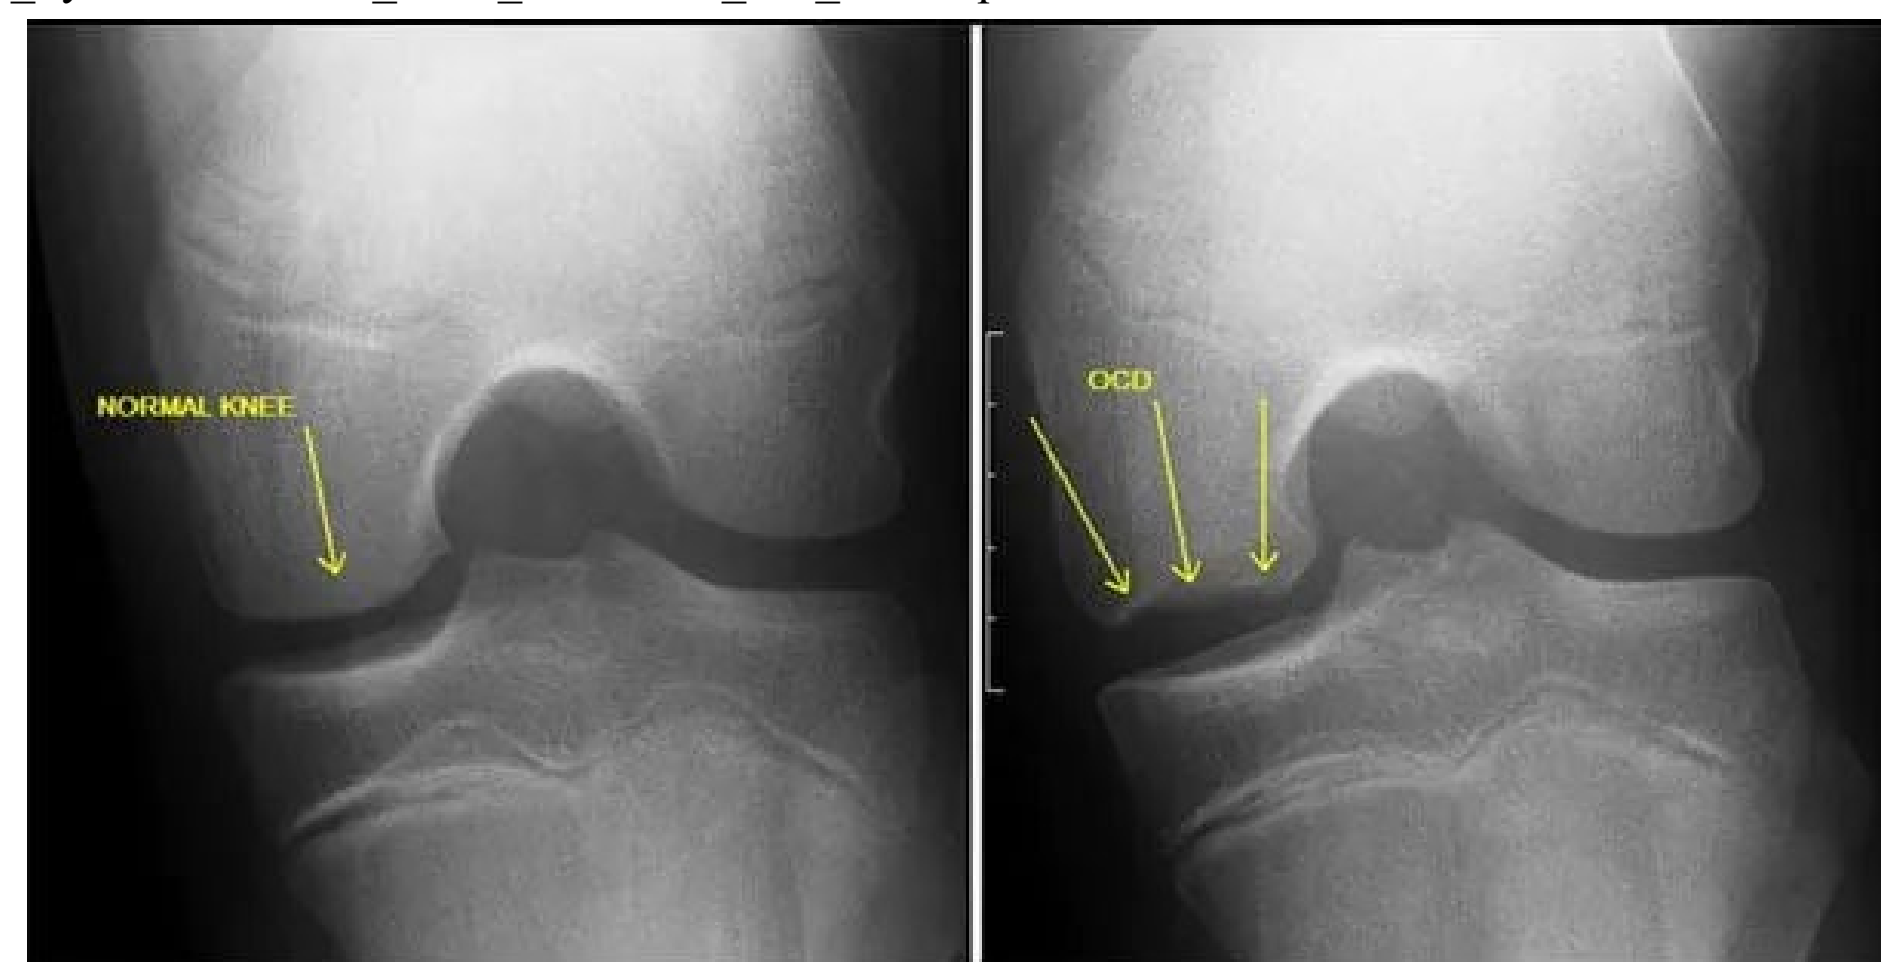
X-ray images of a normal knee joint (left panel) versus a knee joint impacted by OCD (right panel).
